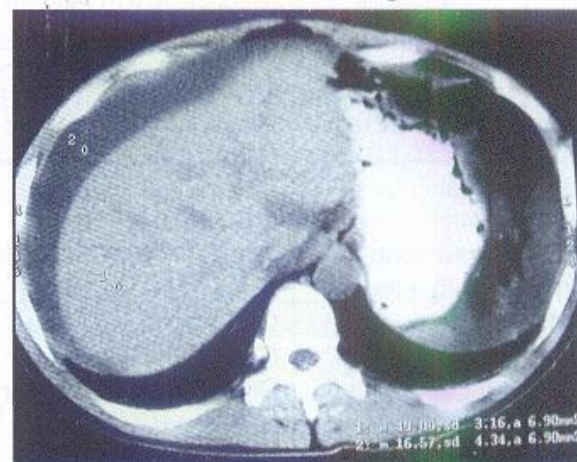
CT scan abdomen showing ascites and secondaries in liver.
